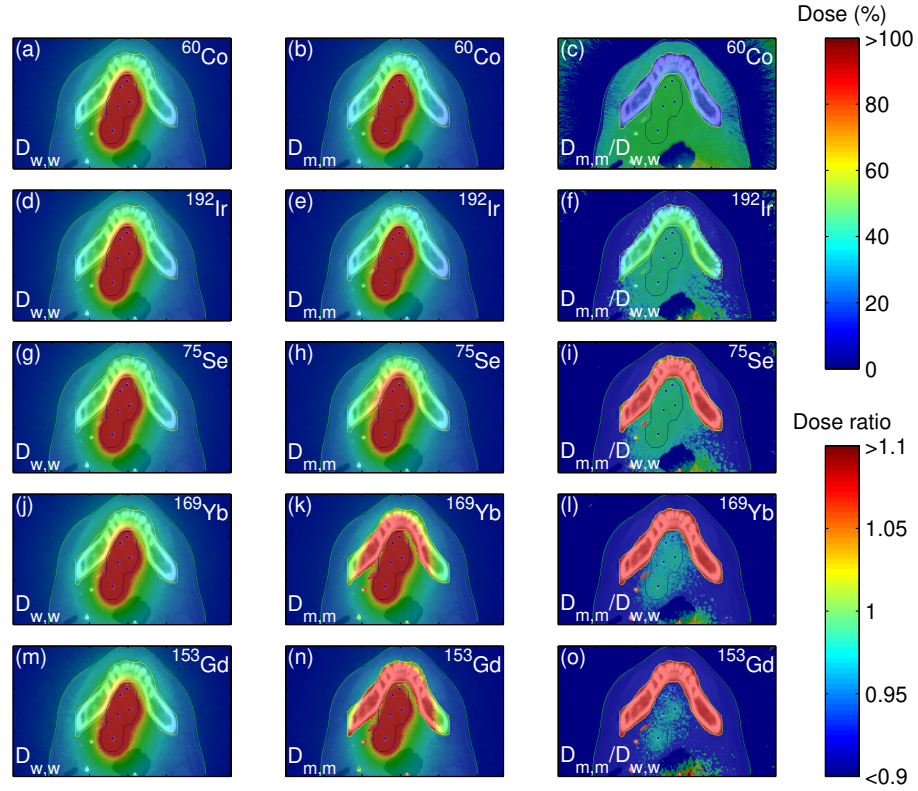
Axial CT slice for an oral tongue brachytherapy case with contours for the PTV (blue), mandible (yellow) and body (green). Dose distributions ($D_{w,w}$ and $D_{m,m}$) and dose ratio maps are overlaid over the patient geometry for (a-c) ^{60}Co , (d-f) ^{192}Ir , (g-i) ^{75}Se , (j-l) ^{169}Yb , and (m-o) ^{153}Gd . Catheter positions are indicated (blue).
